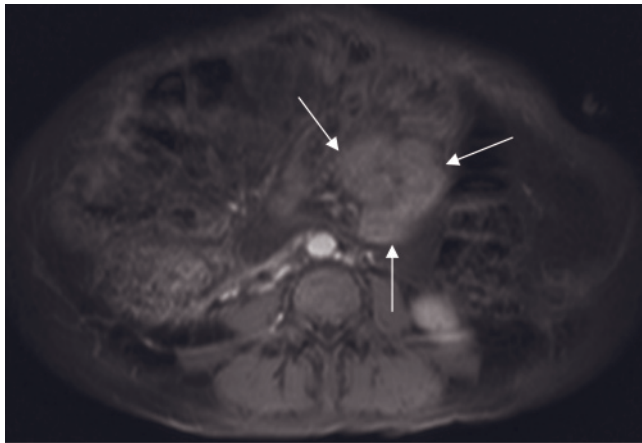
Hiatus hernia and internal hernia. Coronal T2-weighted single-shot echo-train spin-echo (*a*) and transverse immediate postgadolinium SGE (*b*) images. The coronal T2-weighted image demonstrates extension of the stomach (arrows, *a*) above the diaphragm. On the transverse postgadolinium image, the extent of gastric wall enhancement of the herniated part of the stomach (arrows, *b*) is comparable to the remainder of the stomach. Coronal T2-weighted (*c*) image in a second patient. There is a moderately large hiatus hernia (arrow, *c*) in a patient with cirrhosis. Note that stomach, omentum, and ascites protrude through the hernia. Sagittal T1-weighted SGE image (*d*) in a third patient with a history of heartburn. The gastroesophageal junction (long arrow, *d*) is above the diaphragm (arrowheads, *d*), which is diagnostic of a hiatal hernia. Thickening of the esophageal wall (short arrow, *d*) is consistent with reflux esophagitis. Immediate postgadolinium SGE (*e*) and 90-s postgadolinium SGE (*f*) imaging in a fourth patient demonstrate stomach in the lower mediastinum (arrows, *e*, *f*). Gastric rugae are well shown on the gadolinium-enhanced fat-suppressed image (*f*). T2-weighted SSETSE image (*g*) in a fifth patient shows a large hiatal hernia with surrounding herniated fat.
